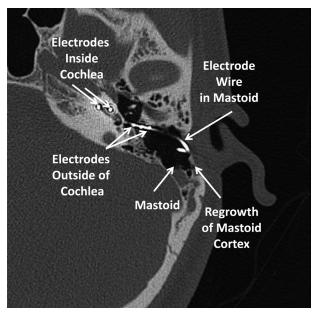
This axial CT image of the left cochlea shows three of the electrodes that are outside the cochlea. A few electrode contact points are visible inside the cochlea. Mastoid cortex regrowth (white line) can be seen with the wire in the mastoid.
